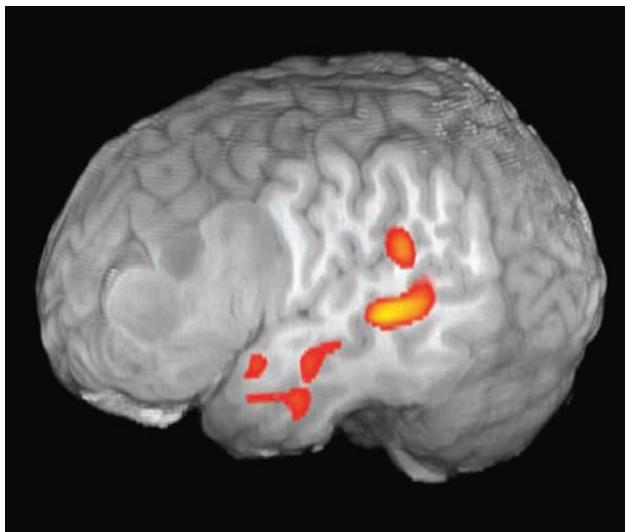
This figure shows a 3-D rendering of activation on the same task as depicted in Figure 6. Enlargement of the gyri in the left frontal opercular region (left inferior and middle frontal gyri) is seen secondary to tumor infiltration, but activation is only seen in the left temporal lobe in receptive speech cortex on this passive listening task performed on a 3-T MRI system, which tends to activate only receptive speech cortex. Thus, the patient is not at risk for developing a receptive (Wernicke's) aphasia with total tumor resection.
